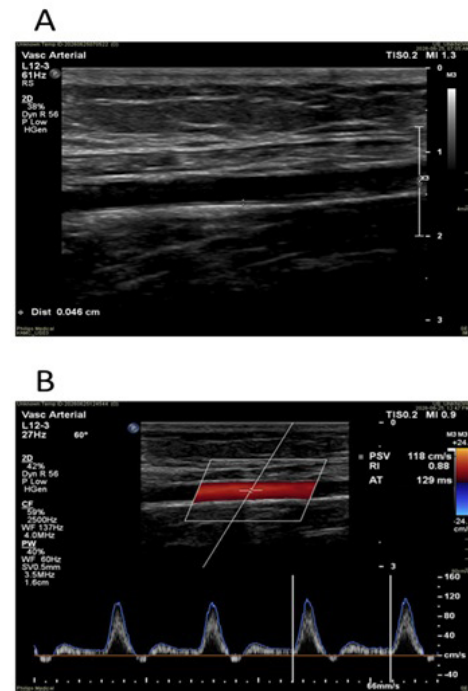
Ultrasound measurement of lower limb arterial parameters. B-mode measurement of wall thickness (A). Doppler measurements of peak systolic velocity (PSV), resistive index (RI), and acceleration time (AT).
